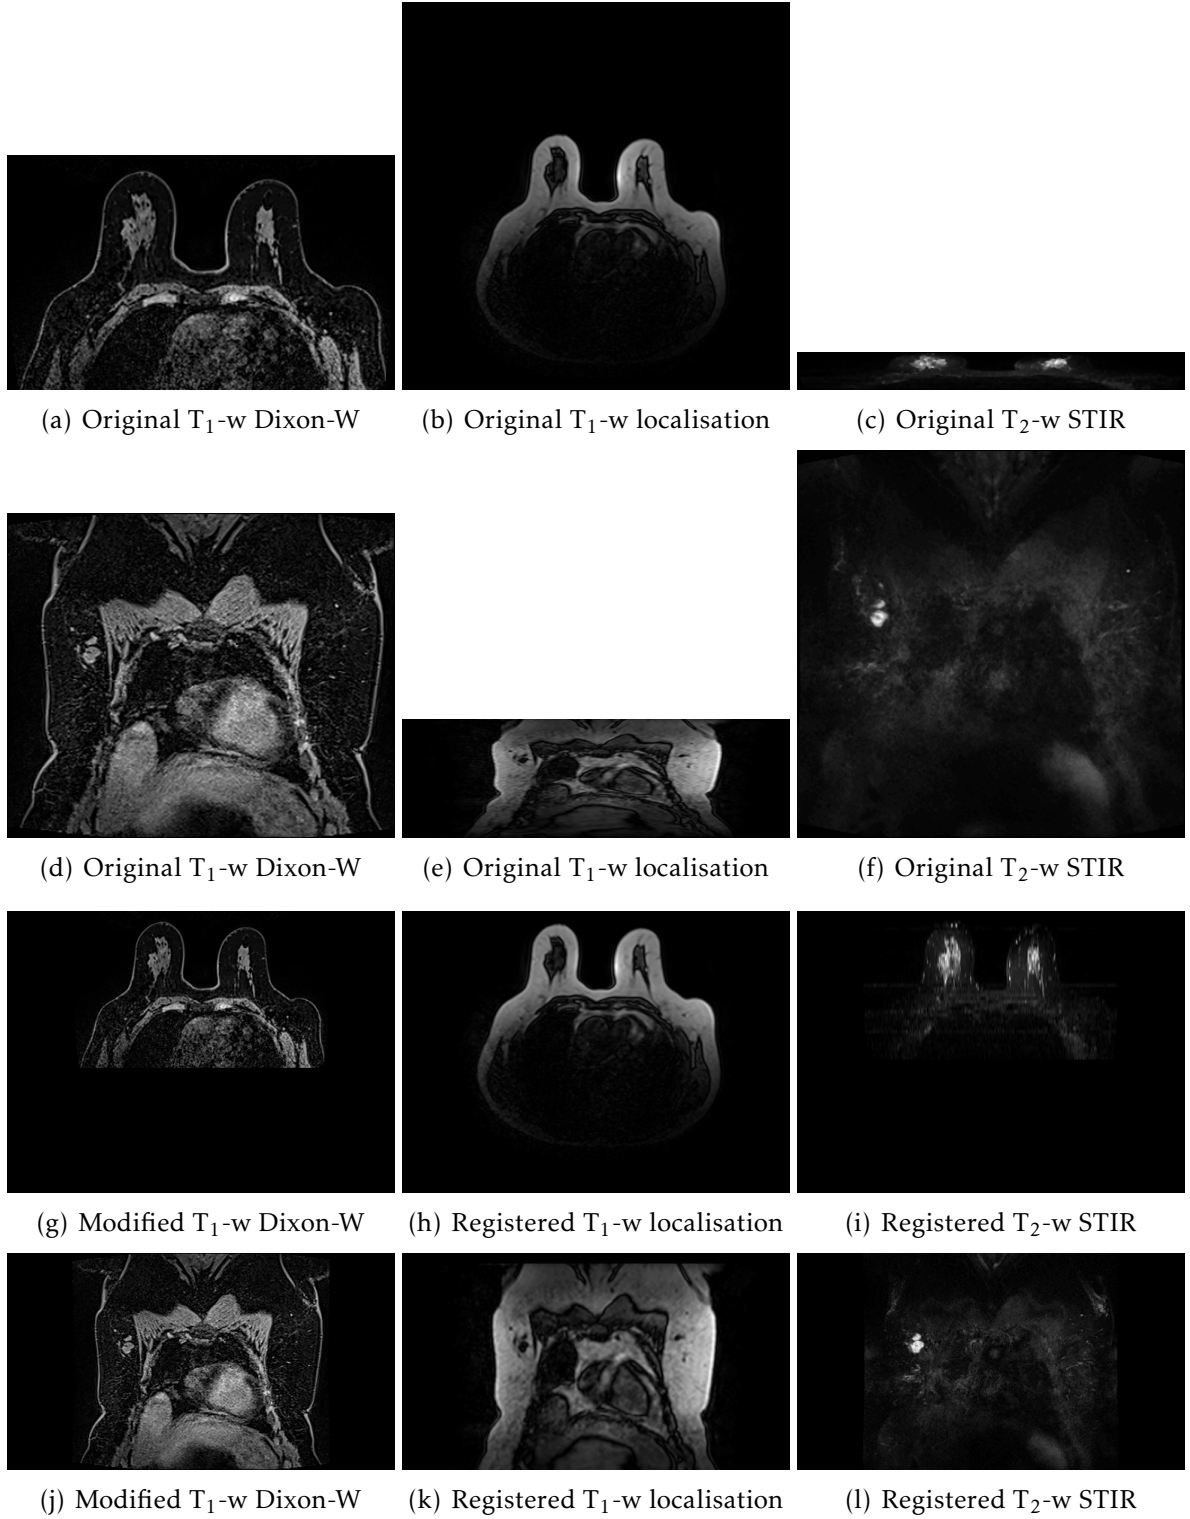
Example of registration of the three image sequences: T_1 -w Dixon-W as static image and T_1 -w localisation and T_2 -w STIR as moving images. (a-c) and (g-i) represent axial slices, and (d-f) and (j-l) represent coronal slices. The size of the images represent the true dimensions of the MR images.
